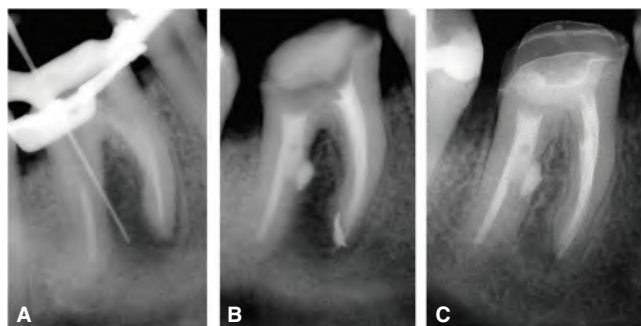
Nonsurgical endodontic retreatment in a perforated mandibular first molar of a 38-year-old female. A. Preoperative radiograph showing a large interradicular radiolucency. An endodontic instrument demonstrates the area of perforation in the distal root caused by inadequate post placement. B. Immediate postoperative radiograph. Endodontic retreatment was done and the perforation sealed with Mineral Trioxide Aggregate (MTA). C. Three-year follow-up radiograph showing resolution of the radiolucency. The tooth is asymptomatic.
